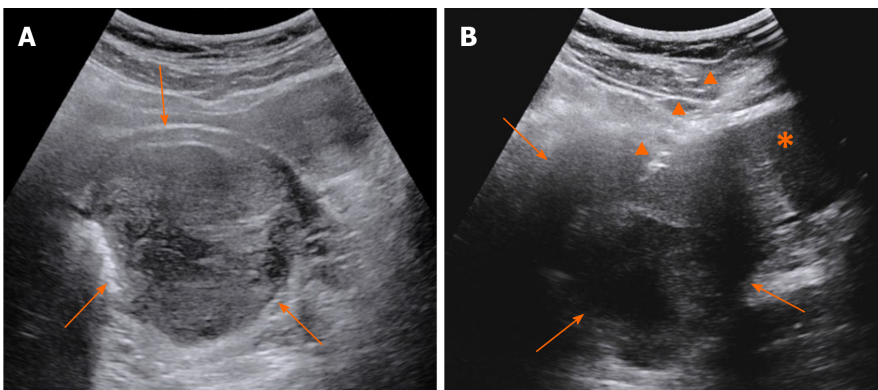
Grey scale ultrasound. A: A mass was demonstrated inside the rectovaginal space in the grey scale images; B: Transabdominal core needle biopsy of the mass. Arrows: The mass; arrow heads: Core needle; asterisk: Uterus cervix.
